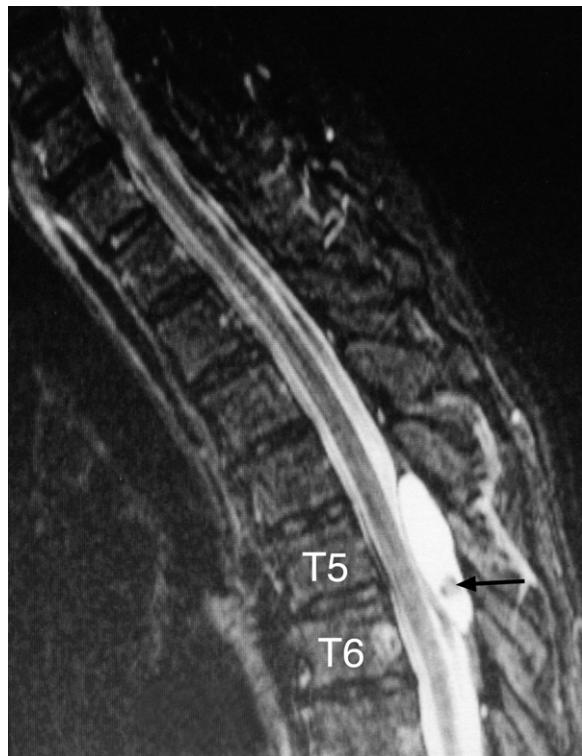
Thoracic spine MRI sagittal T2-weighted image. Note that the lesion is hyperintense compared to the surrounding CSF and has a small hypo-intense component inferiorly (arrow).
